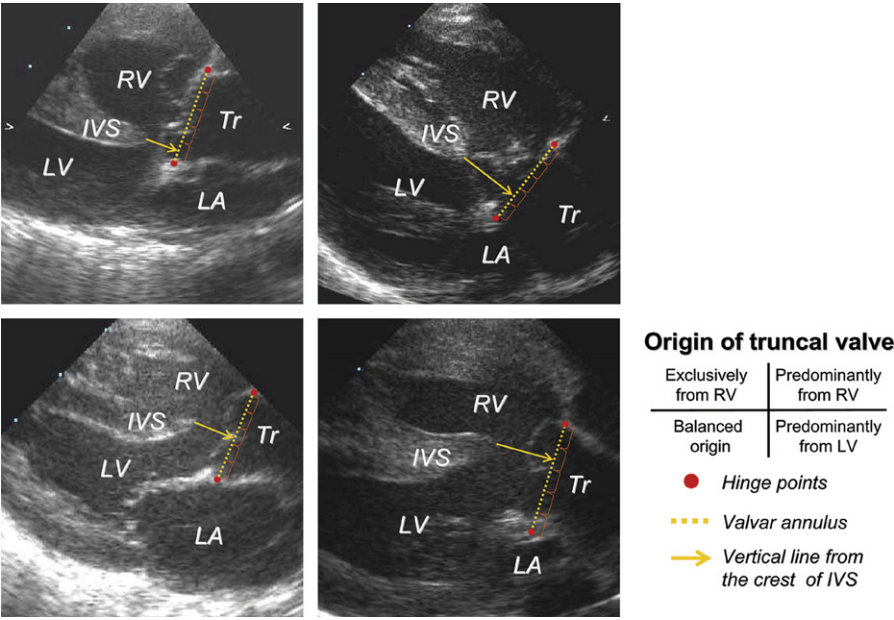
Parasternal long-axis echocardiographic images obtained at end diastole from 4 patients in the clinical series with different types of tricuspid origin. The valvar annulus and its hinge points are marked with the yellow dotted line and the red circle, respectively. The valvar diameter is divided into 5 equal portions (notched line), and tricuspid origin is determined by a perpendicular line from the crest of the ventricular septum indicated with the arrow. IVS, Interventricular septum; LA, left atrium; LV, left ventricle; RV, right ventricle; Tr, tricuspid root.
